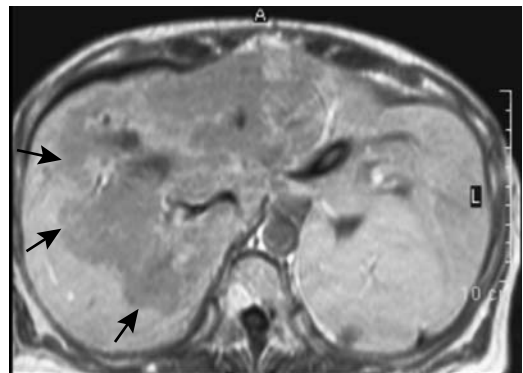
Extensive focal nodular hyperplasia. T1-weighted MRI identifies a hypointense tumor (arrows). (Courtesy of Algidas Basevicius, M.D., Kaunas Medical University, Kaunas, Lithuania.)
